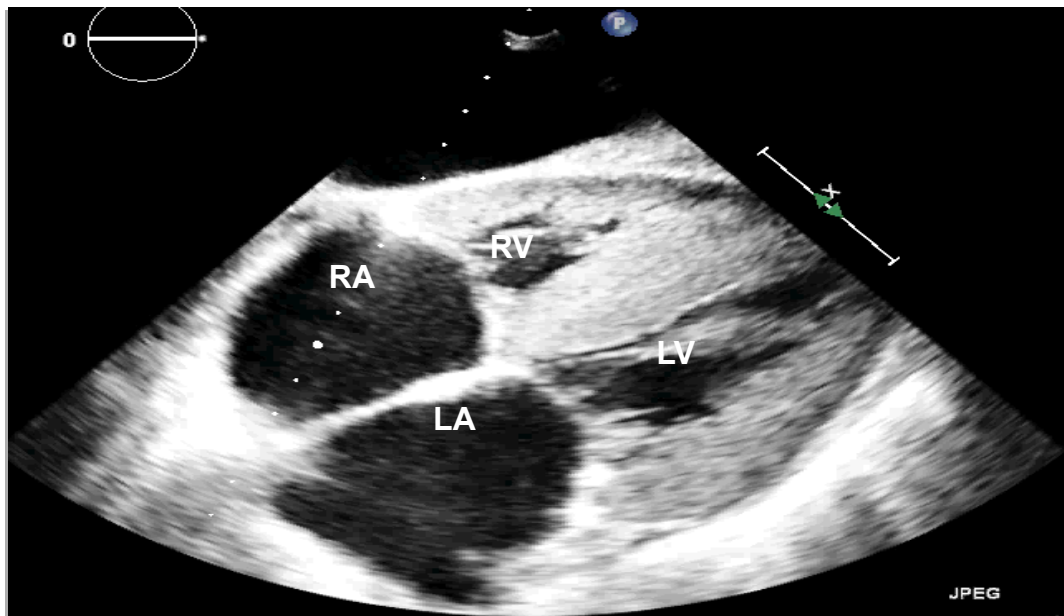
Echocardiography in subcostal projection shows increased thickness of the interatrial septum and biatrial enlargement. LV: left ventricle; RV: right ventricle. RA: right atrium; LA: left atrium.
